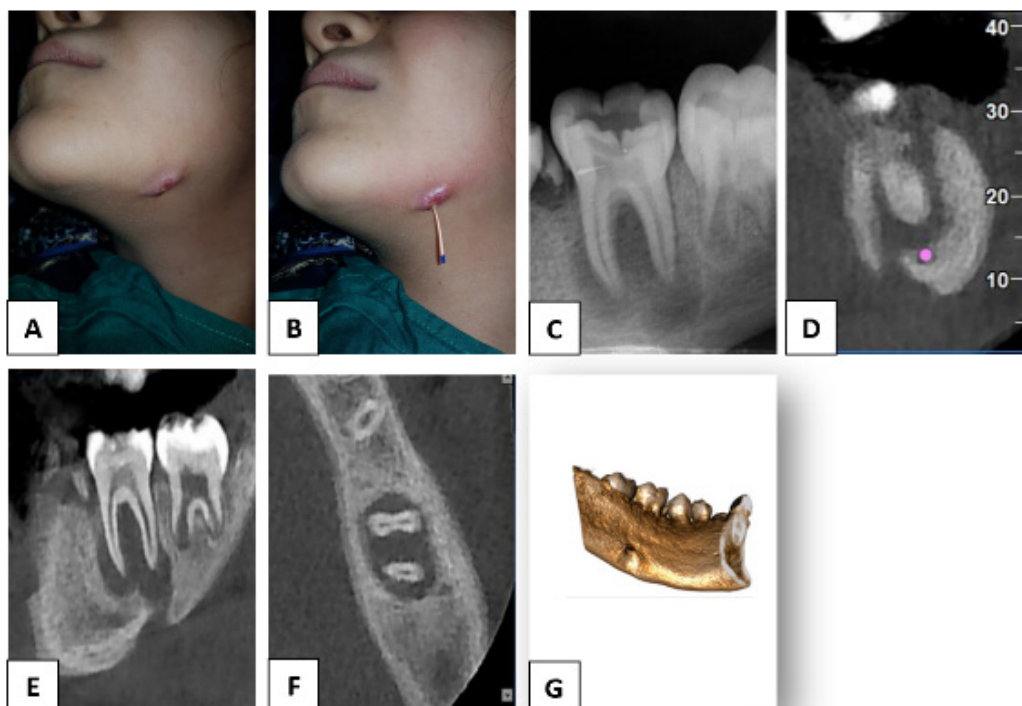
Examination procedures. (A) An extraoral cutaneous sinus tract in the lower jaw region; (B) Gutta-percha tracing; (C) Diagnostic radiograph showing a periapical lesion related to tooth#19; (D) CBCT image (coronal view); (E) CBCT image (sagittal view); (F) CBCT image (axial view); (G) 3-Dimensional Reconstruction
